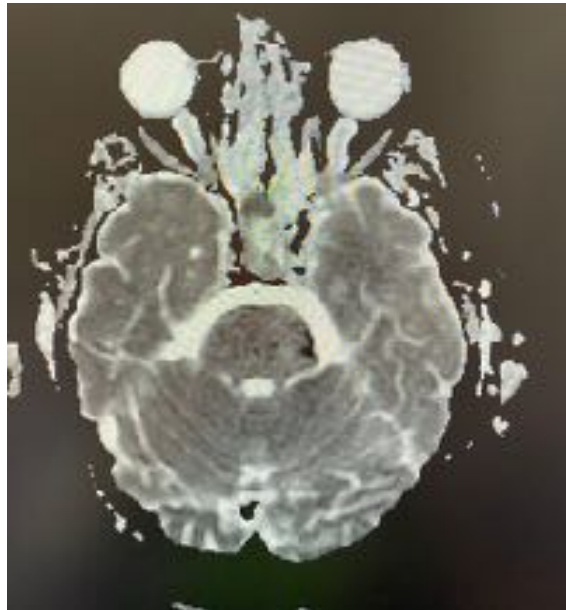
Follow-up brain MRI after completing 21 days of intravenous antibiotics showing resolution of fluid/pus in the occipital horns.
